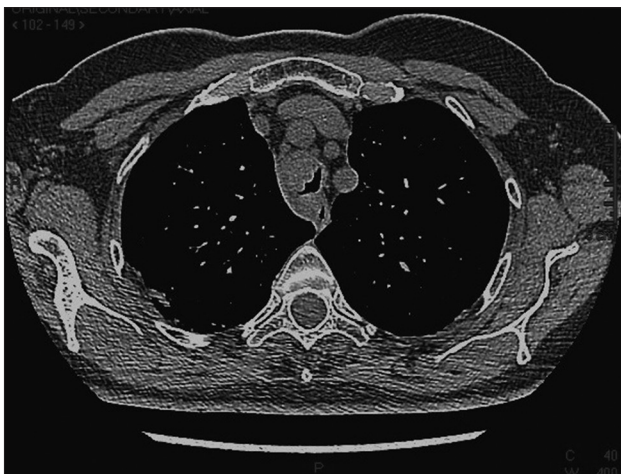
Mucosa-associated lymphoid tissue tracheal lesion on computed tomography scan on March 2013
